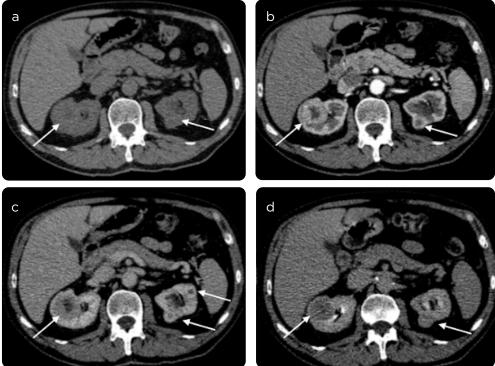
Bilateral oncocytomas. a) CT, phase without contrast medium, b) corticomedullary, c) nephrographic and d) excretory, in both kidneys, with early peripheral enhancement, while the central sector of the tumors has less enhancement, in relation to the central scar. The tumors show less relative enhancement with respect to the healthy renal parenchyma, the central area cannot be differentiated from necrosis that could present a renal cell carcinoma.
